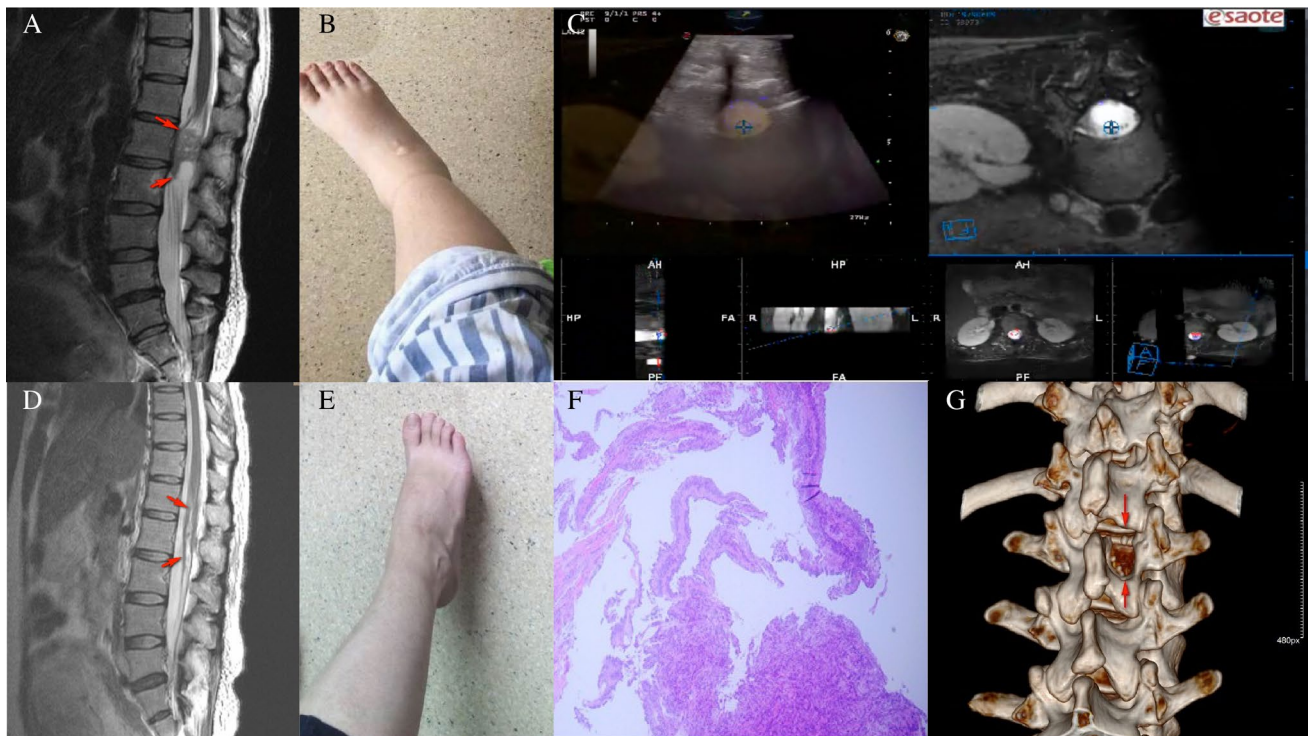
Real-time ultrasound-MRI fusion imaging for accurate locating an intraspinal tumour in a pregnant patient. a Preoperative lumbar MRI revealed an L1 level intraspinal lesion (red arrows indicated a tumour). b The patient presented with severe lower extremity edema (right leg was shown). c Intraoperative VNT based fusion imaging of real-time US (left panel) and MRI (right panel) demonstrated the intraspinal lesion (blue cross) and accurately guided our surgical approach. d MRI performed 3 days after operation showed complete
